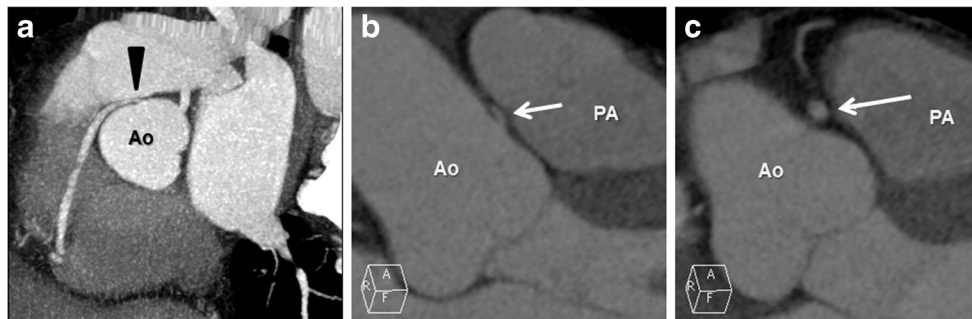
A 71-year-old female presented with exertional chest pain and underwent coronary CTA which demonstrated ACAOS of the right coronary artery. a An oblique sagittal maximum intensity projection image demonstrates the acute angle of takeoff and a slit-like orifice of the anomalous right coronary artery (arrowhead) as it courses between the aorta and the pulmonary artery. b The oblique coronal multiplanar reformat
